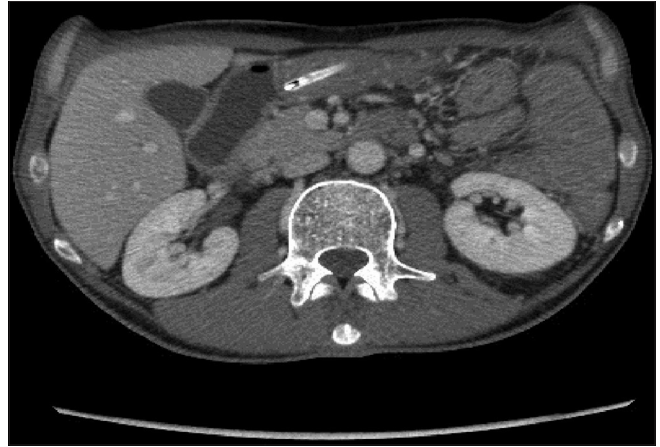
Computed tomography-scan view of second duodenum stenosis due to the lymphoma (with naso-gastric tube inserted)
